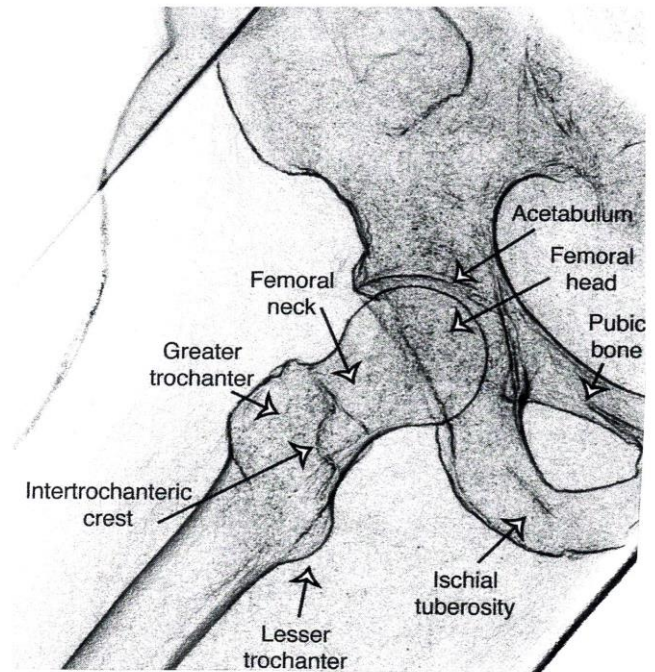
Lateral hip. *Delmar's Radiographic Positioning Volume 1, 1E* © 1998 Delmar Learning, a part of Cengage Learning, Inc. Reproduced by permission. www.cengage.com/permissions.
